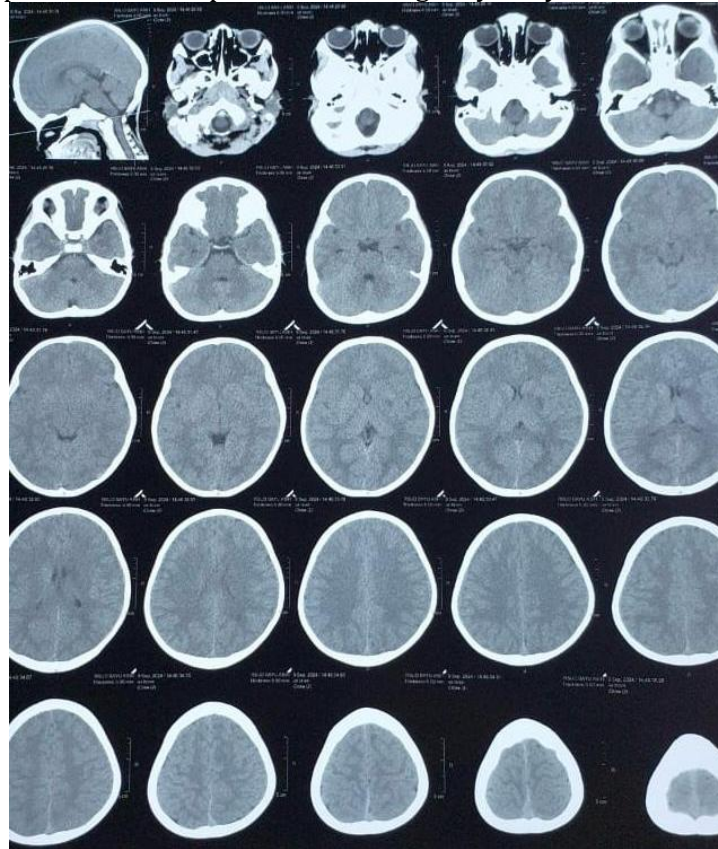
Head CT scan of a 5-year-old boy showing focal ischemia in the left lentiform nucleus
